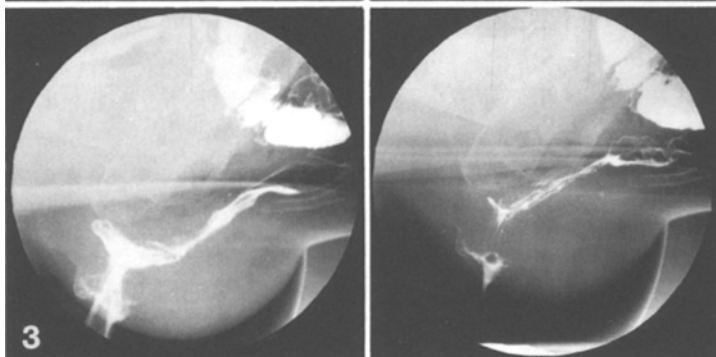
Sequential radiographs during rectal evacuation showing a small rectocele and prolapse of the anterior/superior rectal wall. The changes are most marked in the bottom left frame
